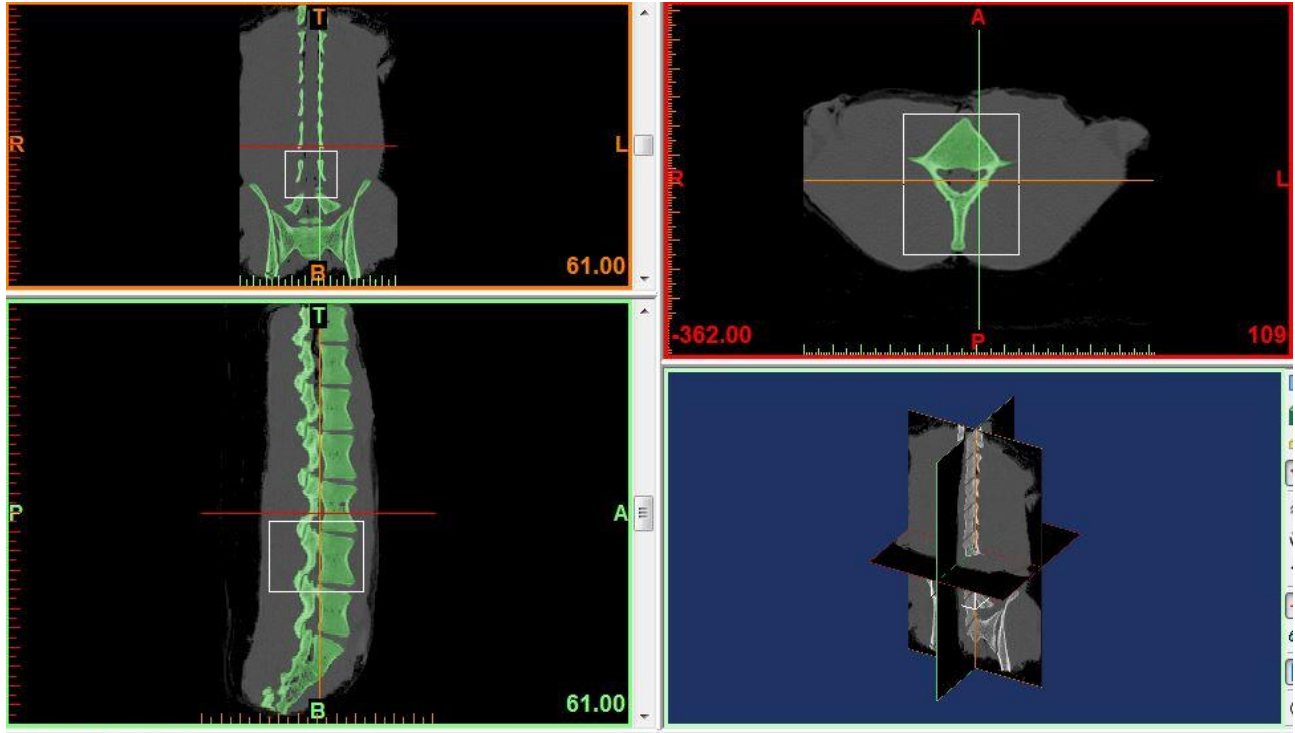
CT scan data highlighting the compact bone in green.
